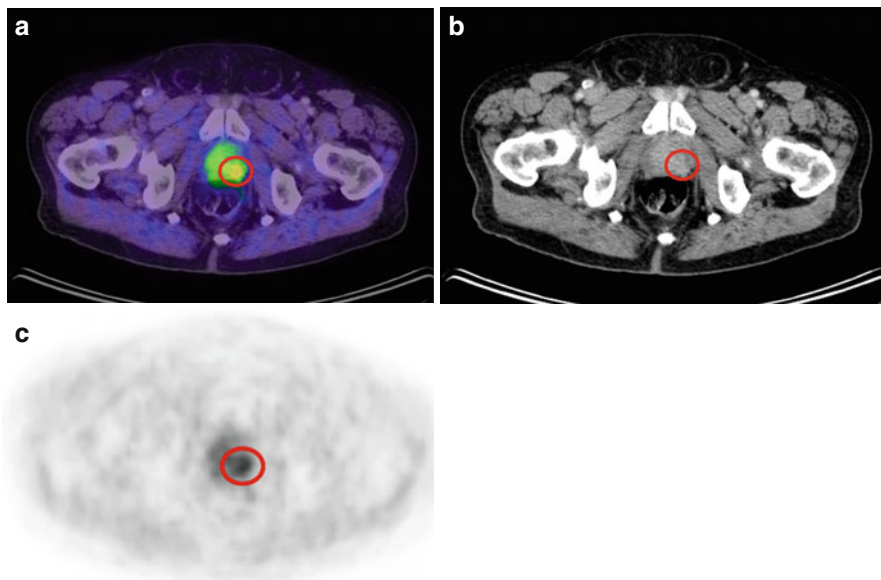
FCh-PET/CT (a), CT (b), and FCh-PET (c) in transverse plane presenting high tracer uptake in a patient with recurrence of prostate cancer (red circle indicating the tumor in the left peripheral zone)
